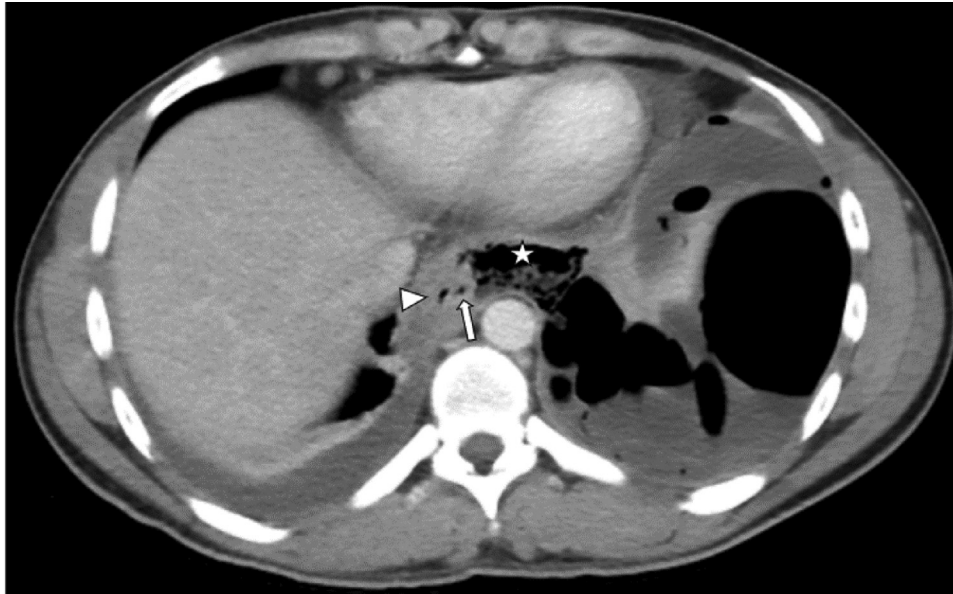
Axial section of contrast-enhanced CT shows rent in the distal esophagus (arrow) just above the gastro-esophageal junction, with adjacent collection (star). Esophageal lumen is also seen. (arrow head).
